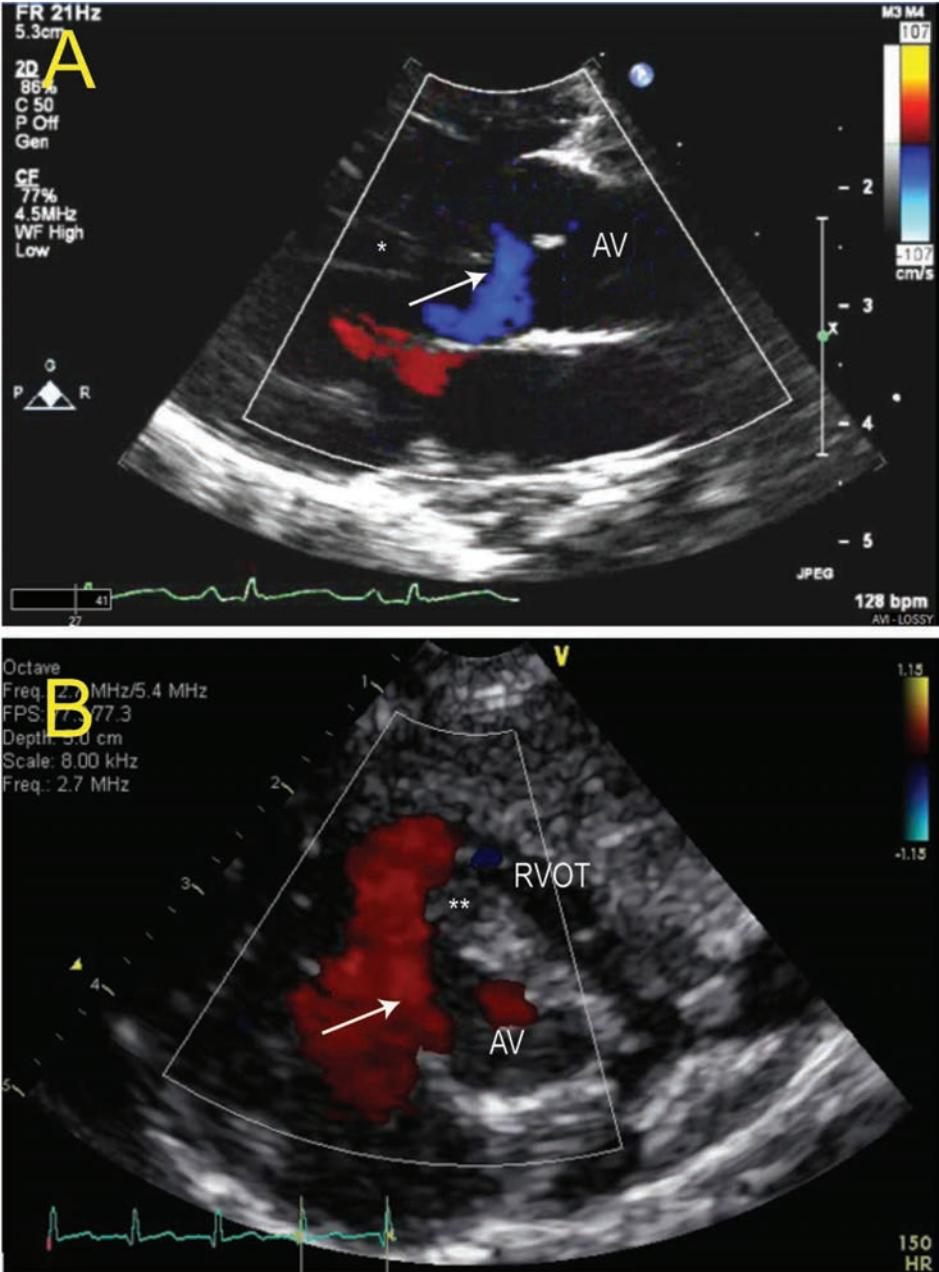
Echocardiography in TOF. The parasternal long-axis view (A) shows a conoventricular septal defect (arrow) with override of the aortic valve (AV) on the interventricular septum (*). The short-axis parasternal view (B) shows an anteriorly deviated infundibular septum () causing significant narrowing of the RVOT. Flow is seen from the VSD (arrow) toward the RVOT.
